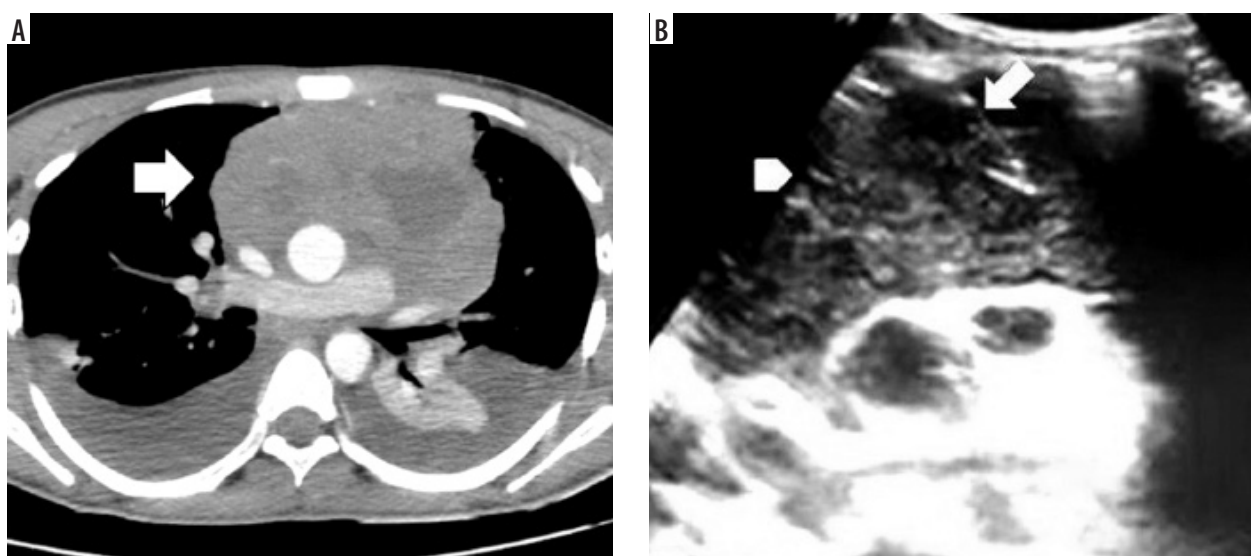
An axial contrast-enhanced CT scan of a 16-year-old male patient demonstrates a large mass in the anterior mediastinum (arrow) (A). The ultrasound (US) image obtained during US-guided percutaneous transthoracic biopsy shows a hypoechoic mass in the anterior mediastinum (arrowhead) with the biopsy needle clearly visible within the lesion (arrow) (B). No complications were observed during or after the procedure, and the pathological diagnosis was B-cell lymphoma
